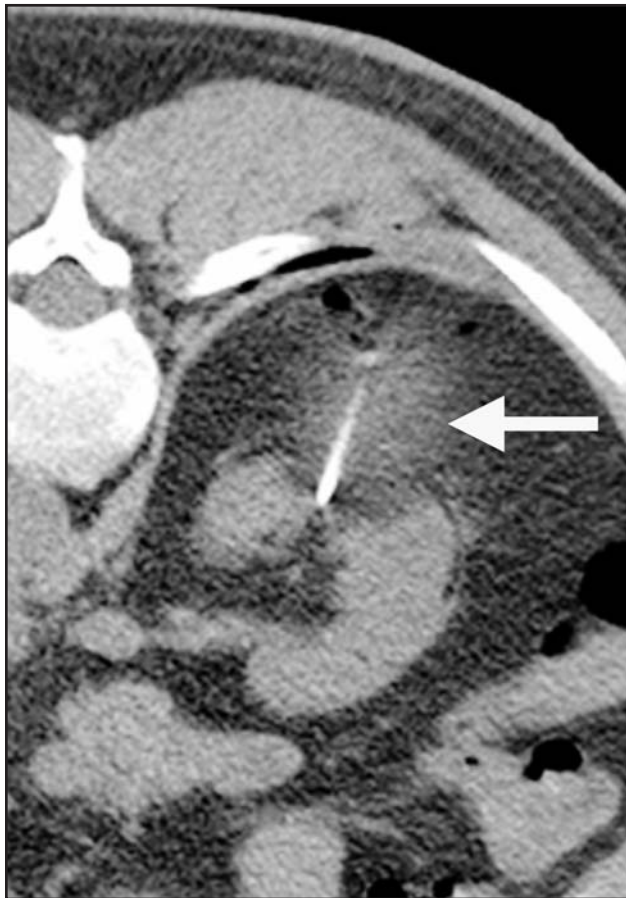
Percutaneous cryoablation of a renal mass under CT guidance. Note the hypodense ice ball formed at the site of the renal mass.
